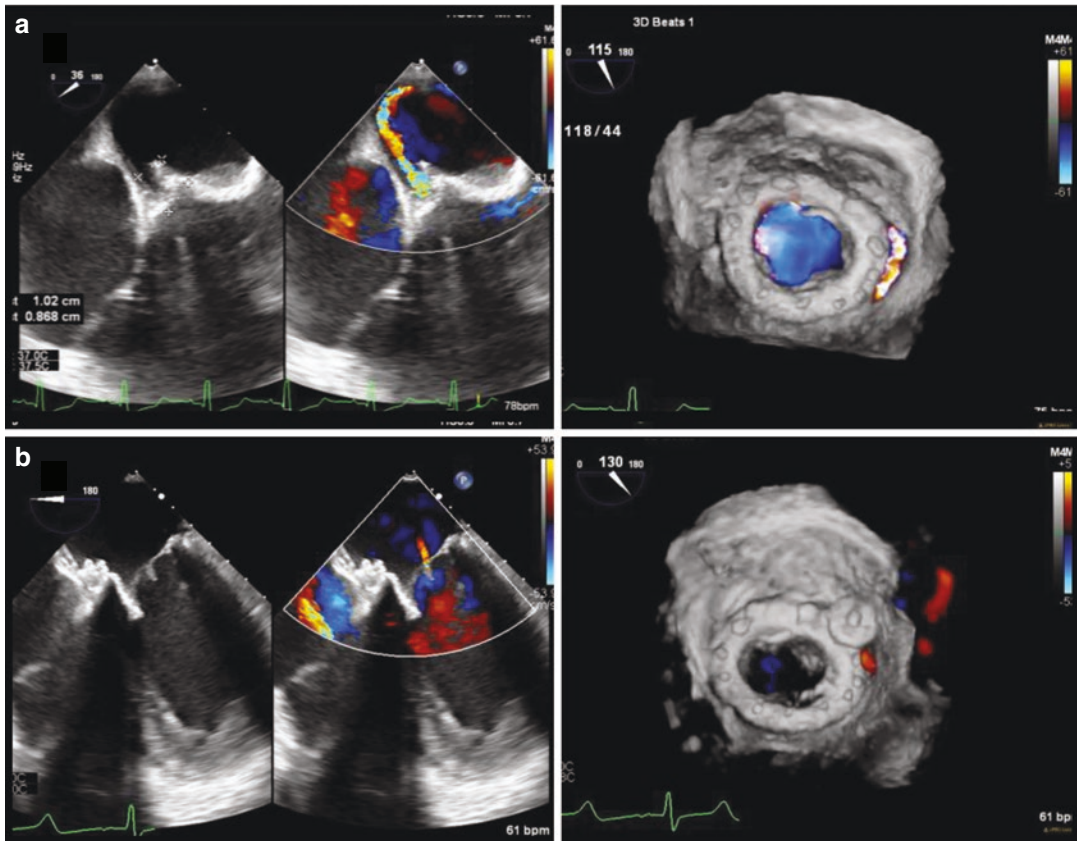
Transcatheter occlusion of a paravalvular leak (Transesophageal echocardiography images). (a) Transesophageal echocardiography (TEE) images of the paravalvular leak at baseline. The left pane is a 2-dimensional and color Doppler image of the leak. The right pane is a 3-dimensional color Doppler image demonstrating the leak along the medial aspect of the mitral prosthesis. (b) TEE images of the paravalvular
